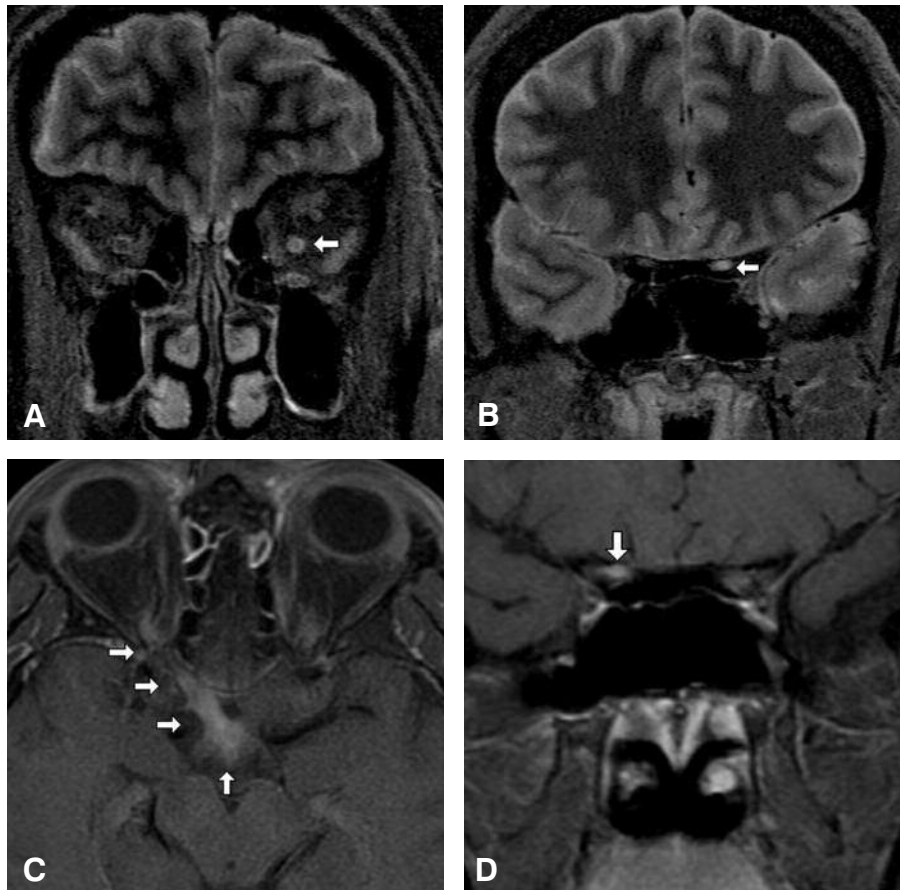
MR images of the brain obtained in February 2007 show acute bilateral optic neuritis involving various segments of the optic nerve. (A and B) Coronal MR images show inflammation of the left optic nerve at two points (arrow) along its course. (C) Axial MR image shows inflammation along the length of the right optic nerve extending to the optic chiasm (arrows). (D) Coronal MR image shows inflammation of the right optic nerve (arrow).
